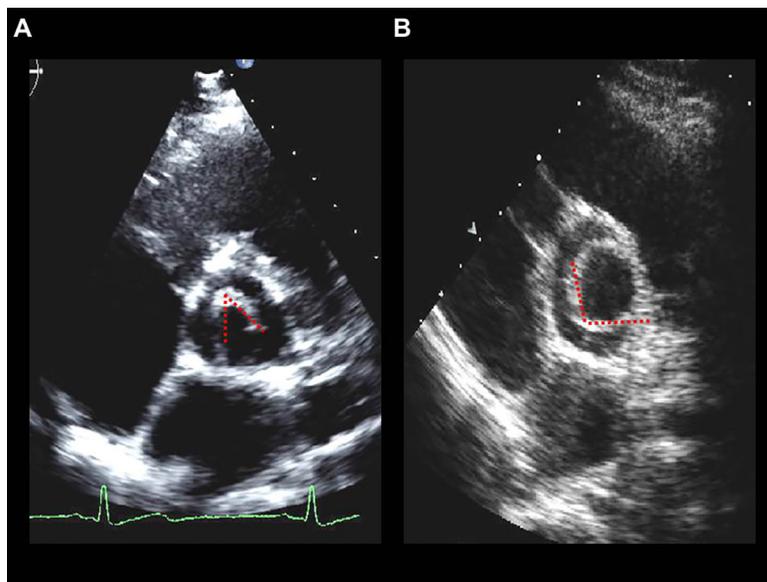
TTE parasternal short-axis views demonstrate the differences between a BAV with acquired commissural fusion (A) and a true congenital UAV (B). BAV with acquired commissural fusion tend to have an ovoid effective orifice and form an acute angle at the point of commissural fusion when open during systolic ejection (A, dotted line). True congenital UAVs will typically have an eccentric and somewhat rounded valvular orifice with a single commissural zone of attachment to the aortic wall. These combine to form a broad, obtuse angle at the site of congenital commissural fusion (B, dotted line).
